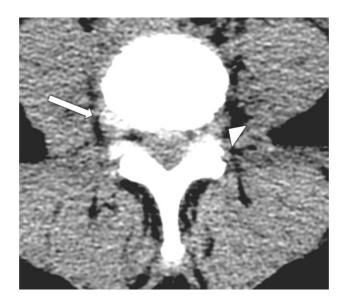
CT: right intra-extraforaminal disc herniation, partially calcified (arrow). The normal course of the contralateral root is shown by arrowhead
